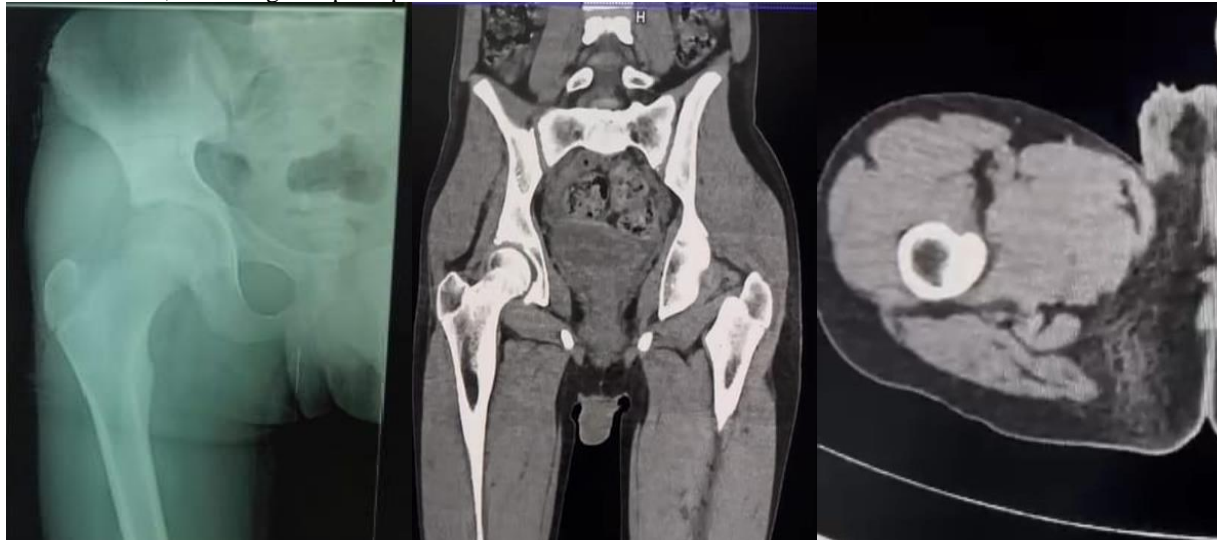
Images showing 3 month old post op follow-up x-ray, Coronal and axial sections of CT (from left to right).
